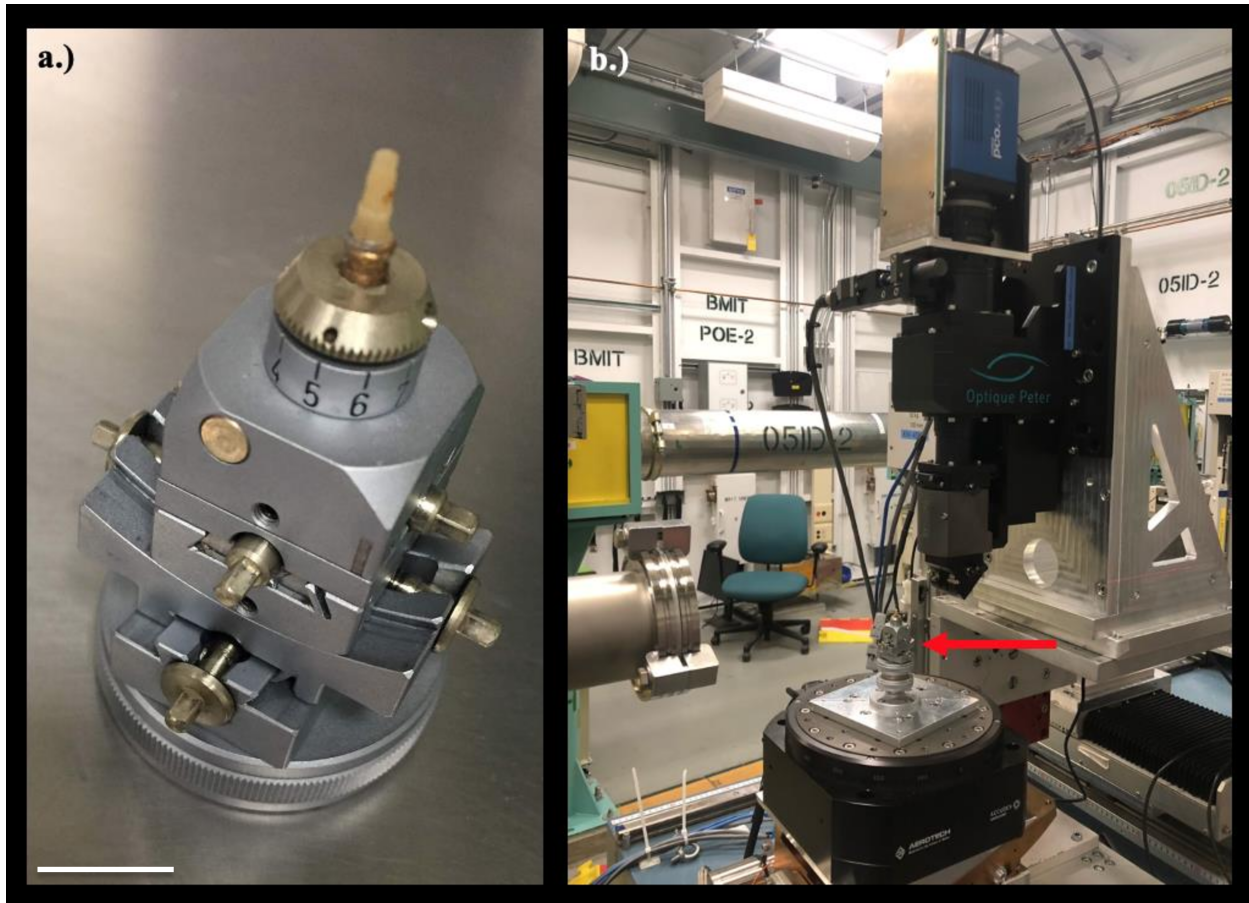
Photos from SR μ CT imaging experimental setup. a.) demonstrates bone sample core mounted onto goniometer. Scale bar set to 1cm. b.) demonstrates goniometer (demarcated by red arrow) mounted into beam path and in field of view of the live function graphic user interface.
